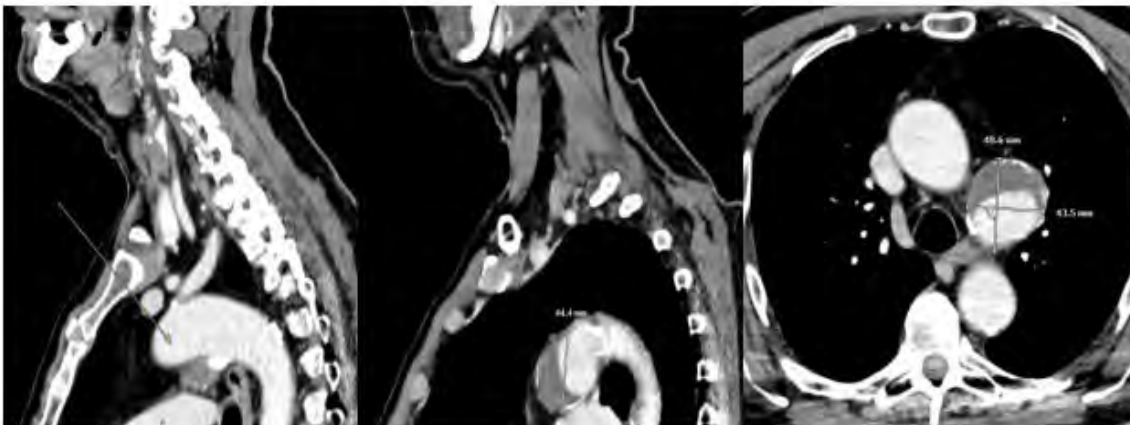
Contrast enhanced CT of neck and chest reveal anteroinferiorly projecting aneurysm with peripheral mural thrombus, arising from the ductus diverticulum of the thoracic aorta immediately distal to the origin of the left subclavian artery.
